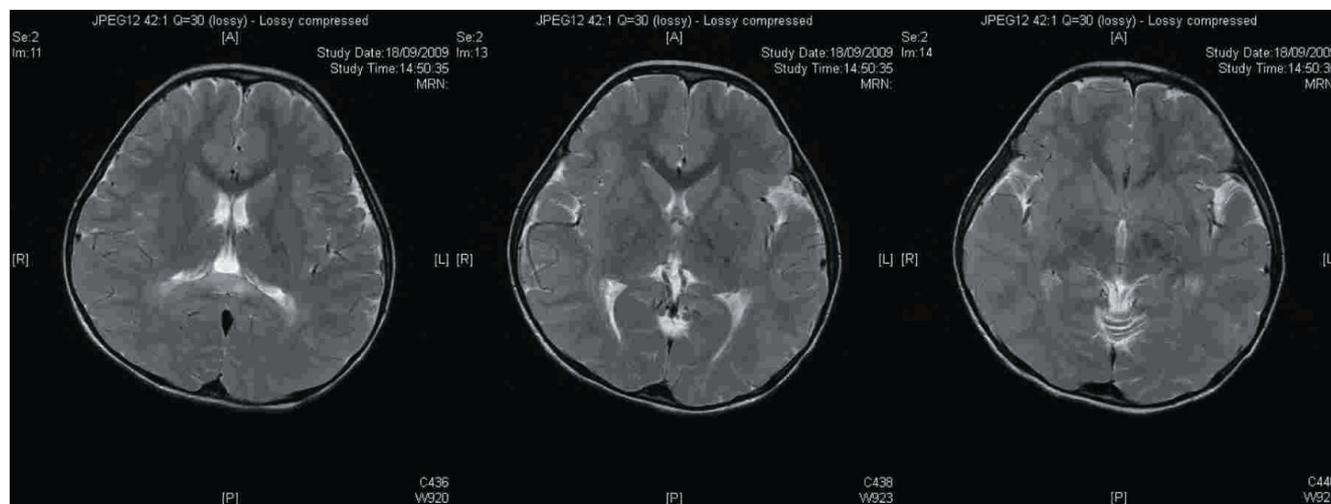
Cranial MRI at age 4 years 10 months showing T2 hyperintensity involving bilateral parieto-occipital regions and splenium of corpus callosum.
